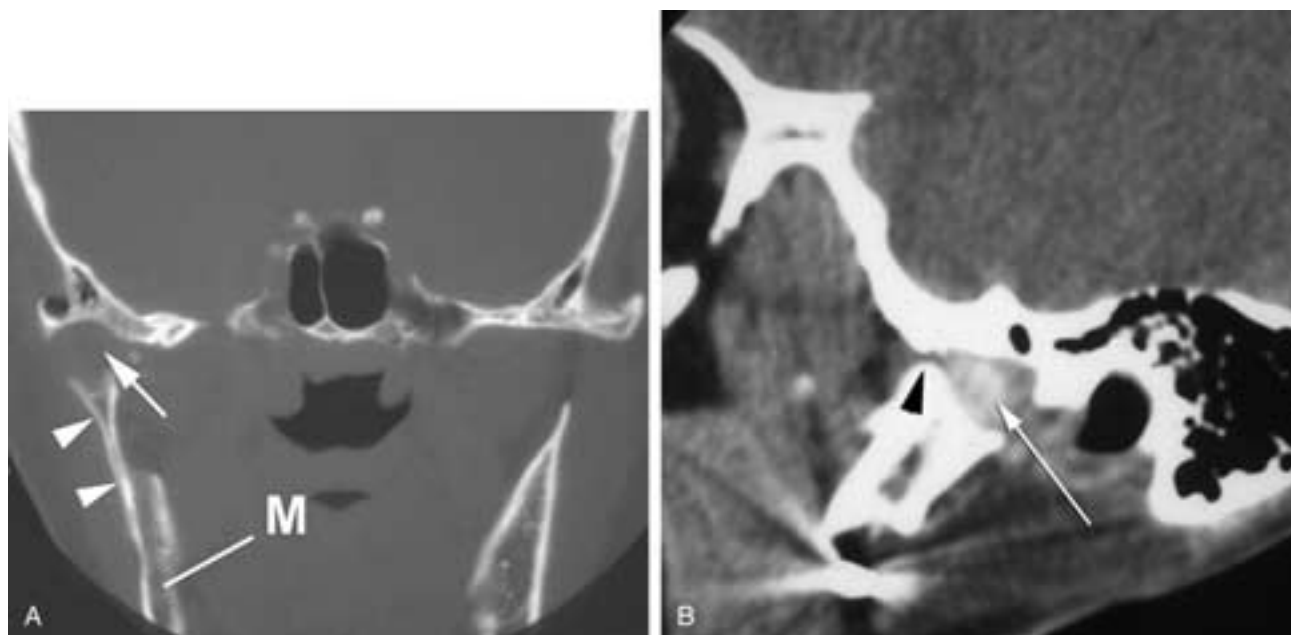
Costochondral graft CT. A, Coronal CT scan shows the osseous portion of the costochondral graft (arrowheads) attached to the lateral aspect of the native mandible (*M*). The chondral part of the graft (arrow) is seen as a lucency separating the osseous part of the graft from the glenoid. B, The cartilage portion of the graft (arrow) is seen clearly on the sagittal reformatted image. Note that the edge of the osseous portion of the graft (arrowhead) is very close to the articular eminence.
